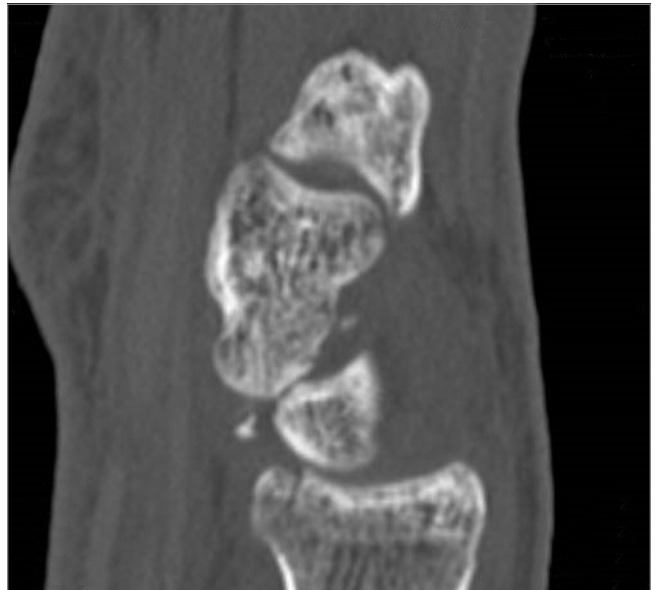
Computed tomography shows lunate volar lip fracture and radius fracture.
